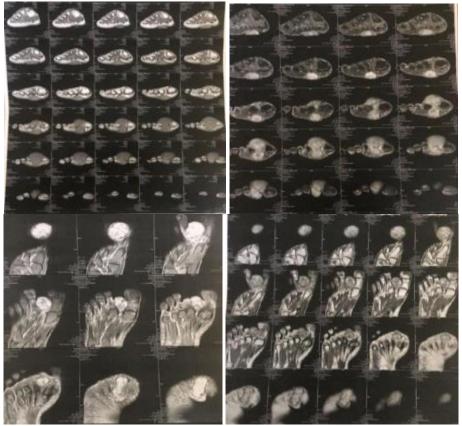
MRI images of the foot showing a soft tissue tumor process initially suggesting a sarcomatous origin
